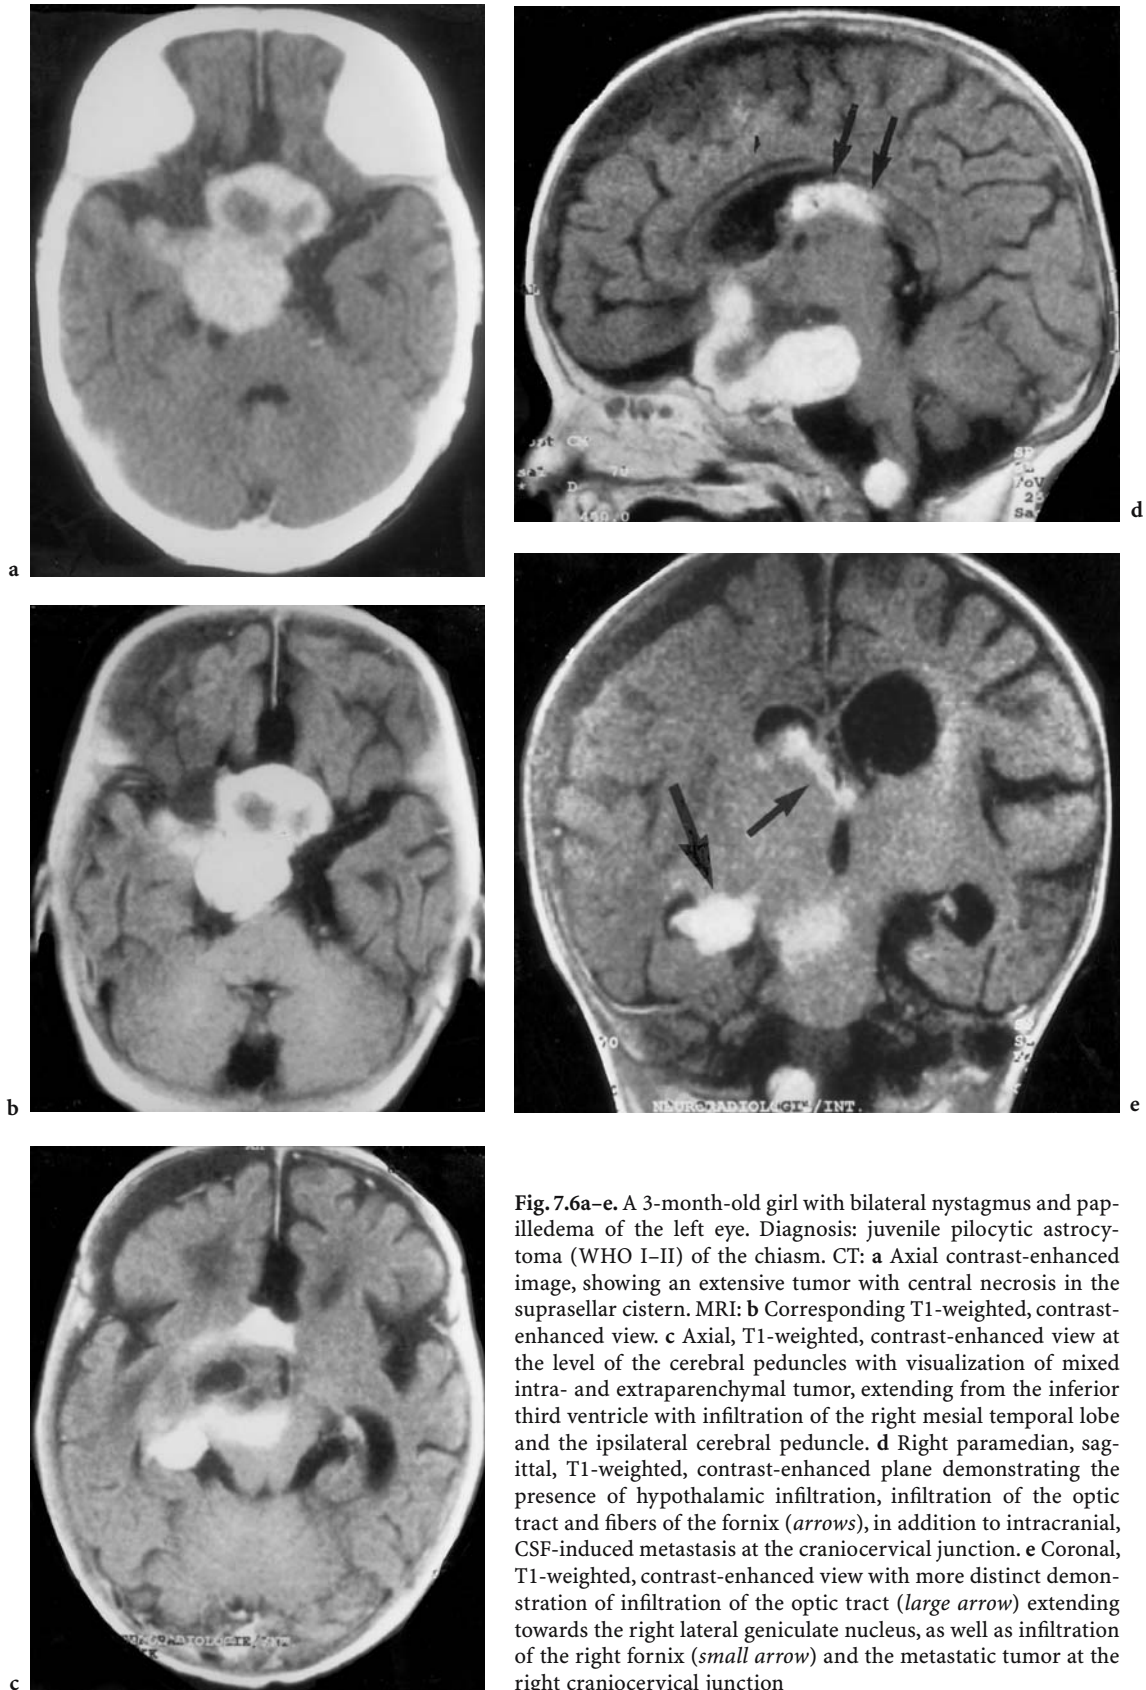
A 3-month-old girl with bilateral nystagmus and papilledema of the left eye. Diagnosis: juvenile pilocytic astrocytoma (WHO I-II) of the chiasm. CT: a Axial contrast-enhanced image, showing an extensive tumor with central necrosis in the suprasellar cistern. MRI: b Corresponding T1-weighted, contrast-enhanced view. c Axial, T1-weighted, contrast-enhanced view at the level of the cerebral peduncles with visualization of mixed intra- and extraparenchymal tumor, extending from the inferior third ventricle with infiltration of the right mesial temporal lobe and the ipsilateral cerebral peduncle. d Right paramedian, sagittal, T1-weighted, contrast-enhanced plane demonstrating the presence of hypothalamic infiltration, infiltration of the optic tract and fibers of the fornix (*arrows*), in addition to intracranial, CSF-induced metastasis at the craniocervical junction. e Coronal, T1-weighted, contrast-enhanced view with more distinct demonstration of infiltration of the optic tract (*large arrow*) extending towards the right lateral geniculate nucleus, as well as infiltration of the right fornix (*small arrow*) and the metastatic tumor at the right craniocervical junction
